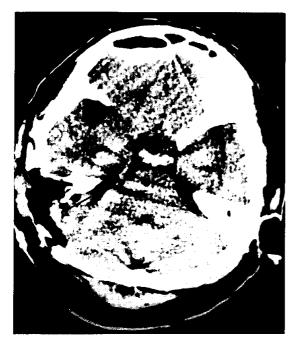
Postoperative brain CT (arrow: direction of entry)
